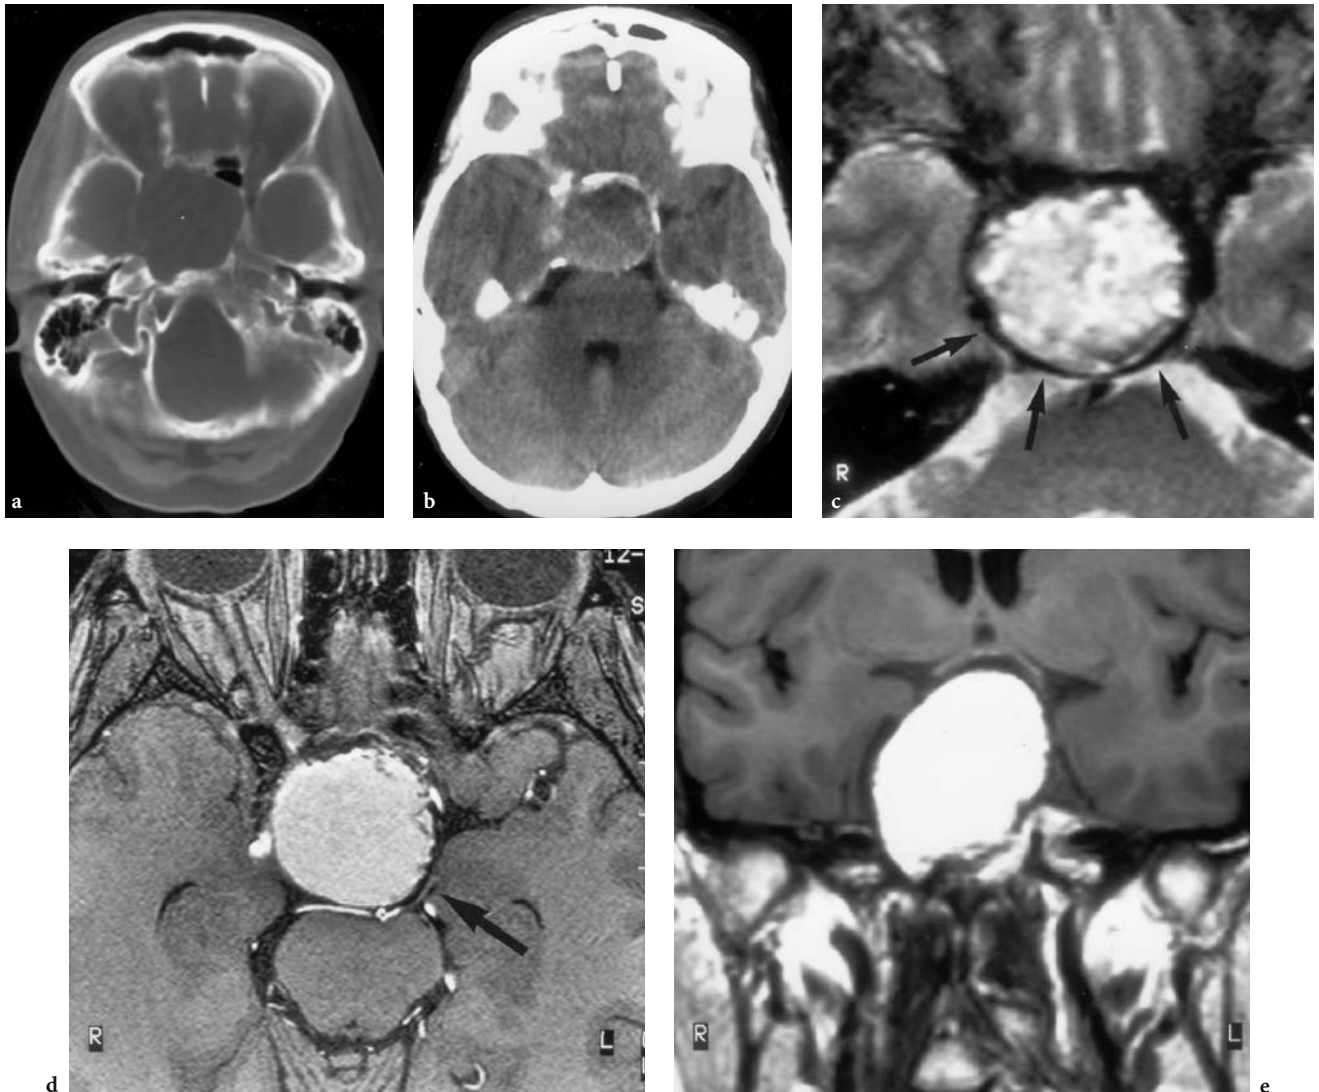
A 40-year-old woman with progressive visual deficit persisting for 15 months, as well as slowly progressing headache and dysmenorrhea, presenting with left temporal hemianopsia. Diagnosis: cholesterol granuloma of the sphenoid sinus. Axial CT: a Bone window at the skull base, demonstrating substantial widening with erosion (no destruction), especially of the right side of the sphenoid sinus, including the region of the right optic and reaching the carotid canal. b At the suprasellar level, an isodense, sharply circumscribed mass occupies the pentagon cistern. MRI: c Axial T2-weighted view showing an irregular hyperintense mass in the sphenoid sinus and sellar floor region, sparing the bony cortex of the clivus (hypointensity, *arrows*). d Axial T1-weighted native HR image at the level of the right optic canal, with homogeneous hyperintensity of the granuloma. Note slight compression of the brainstem with dislocation of the left oculomotor nerve (N III) (*arrow*). e Coronal T1-weighted image visualizing substantial craniocaudal extension of the mass with inferior compression of the chiasm
